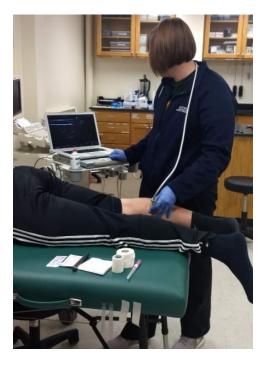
Diagnostic Ultrasound Measuring Adipose Thickness.
